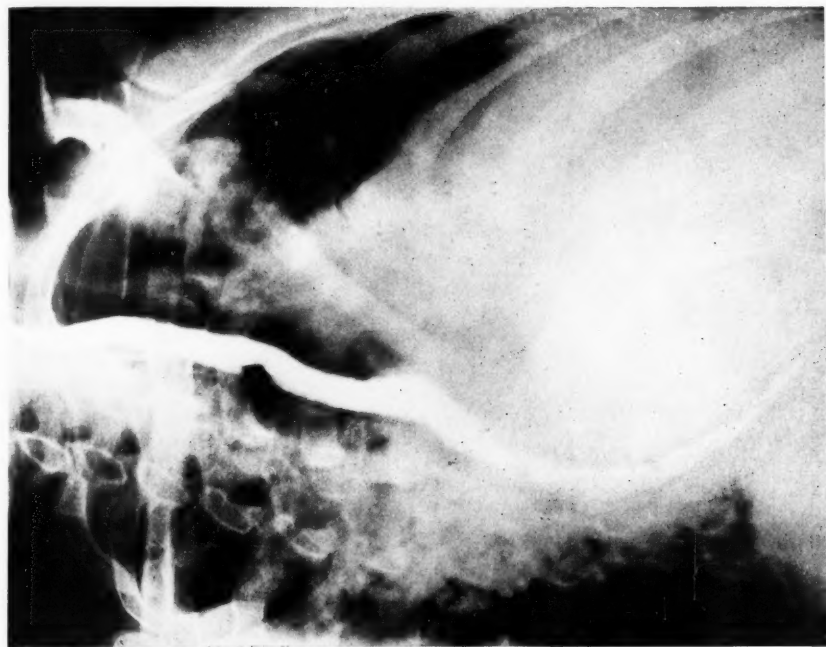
Case 8. Right anterior oblique radiograph showing that the barium-filled oesophagus is displaced posteriorly by the enlarged left auricle. No erosion of vertebrae is seen in this view
